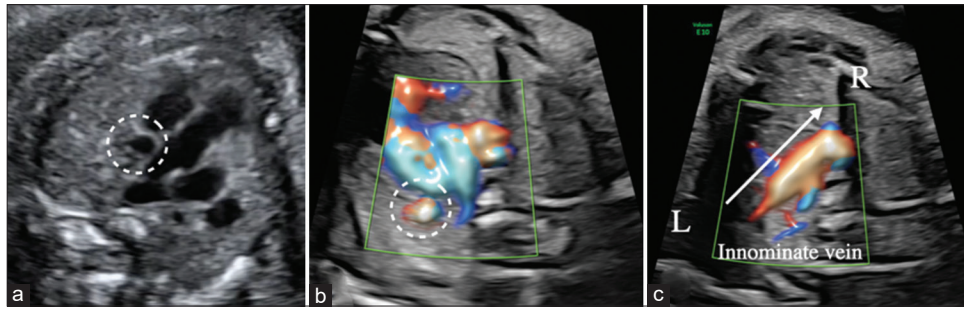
Prenatal ultrasound findings in a fetal heart at 26 weeks of gestation in a case of supracardiac total anomalous pulmonary venous return. (a) An additional vertical vein can be seen in the left side of the pulmonary artery (dashed line circle), (b) color Doppler mapping of a corresponding location (a) (dashed line circle), (c) prominent innominate vein due to excess flow (following the arrow direction) from the ascending vertical vein
